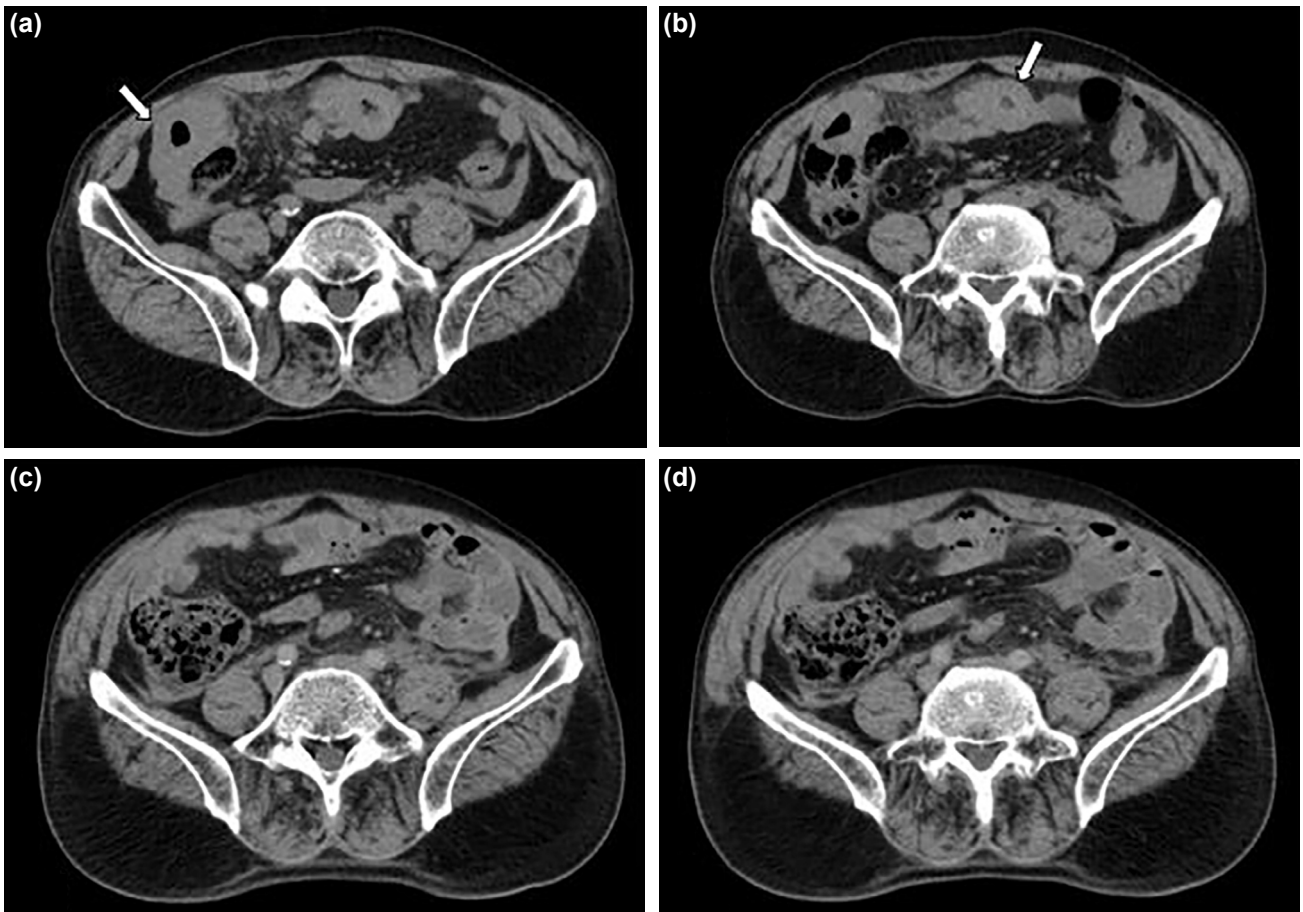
Intestinal mural hemorrhage. (a) and (b) Segmented and high-density small intestine wall thickening (arrows) on the initial unenhanced abdominal computed tomography (CT) and (c) and (d) small intestines with normal wall thickness on contrast-enhanced abdominal CT taken 3 days after.
